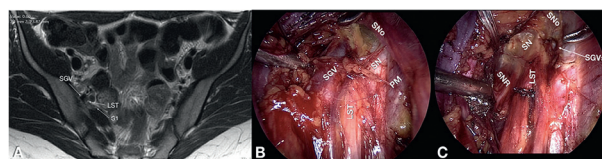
MRI demonstrating variant SGV (vSGV) compressing the LST (lumbosacral trunk) and S1 nerve root – A. Intraoperative findings before & after decompression; B – Before decompression: Variant SGV compressing LST (lumbosacral trunk) & SN (sciatic nerve); C – After decompression LST, SN and SNR (sciatic nerve roots) visible after vSGV ligation; SNo (sciatic notch); PM (psoas muscle).
